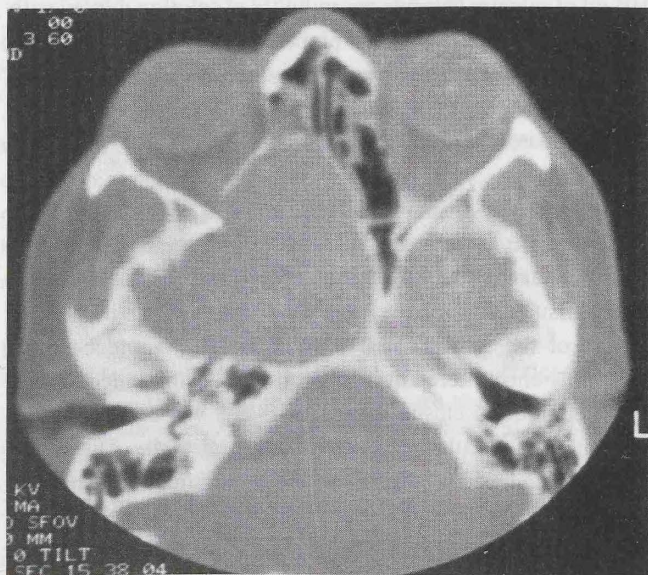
Axial CT-scan of a giant mucocoele of the sphenoid sinus revealing erosion of the basiocciput and extending into the middle and posterior cranial fossae.
